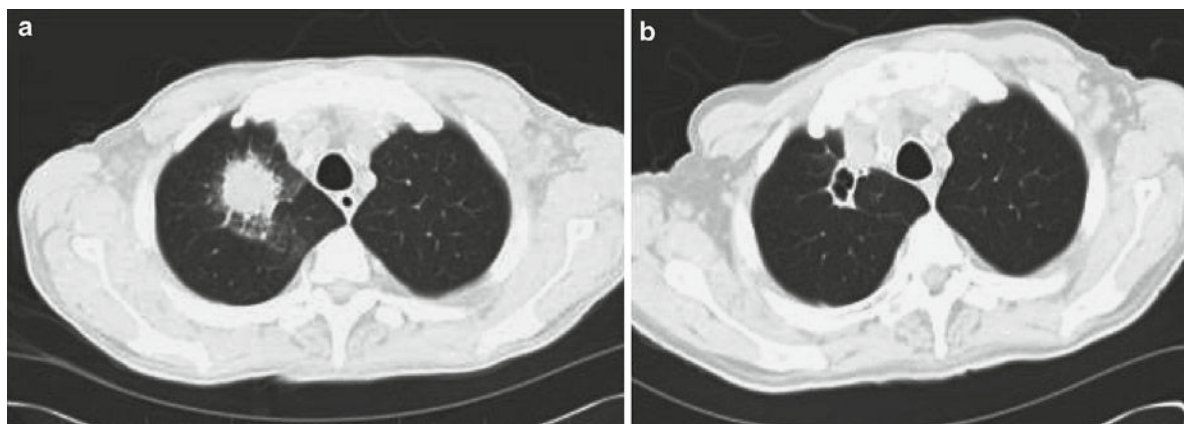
(a) High resolution CT scan of the chest showing right upper lobe nodule with the Halo sign in a patient with non-Hodgkin's lymphoma and neutropenia who developed IPA.
